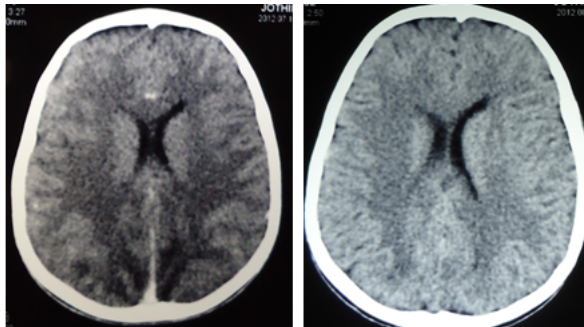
CT brain showing bilateral hypodensities in both parieto occipital regions
